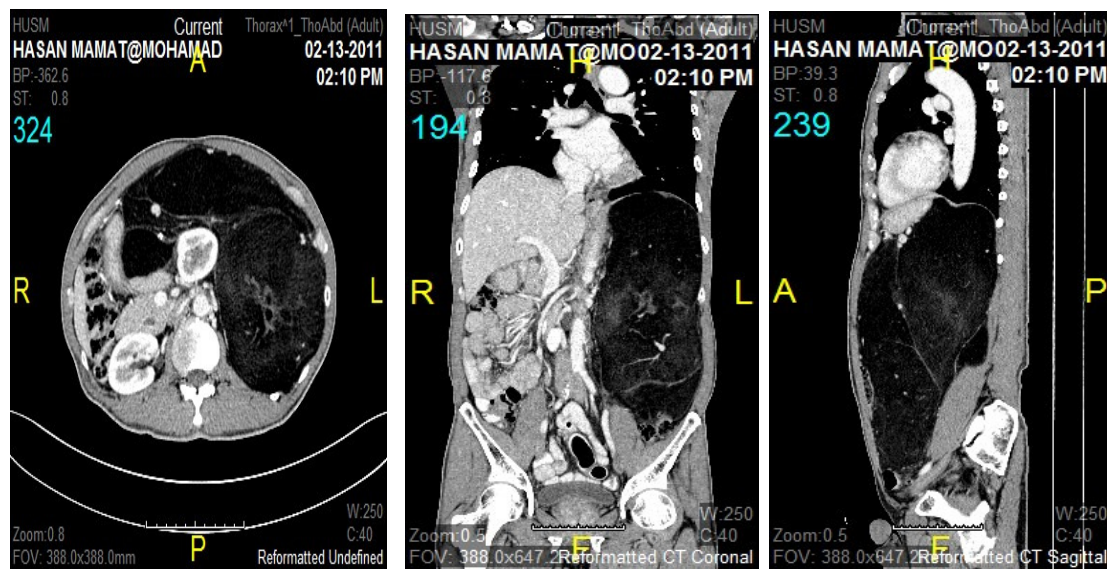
CT scan of our patient showing a left-sided retroperitoneal mass pushing most of the abdominal organs to the right.
